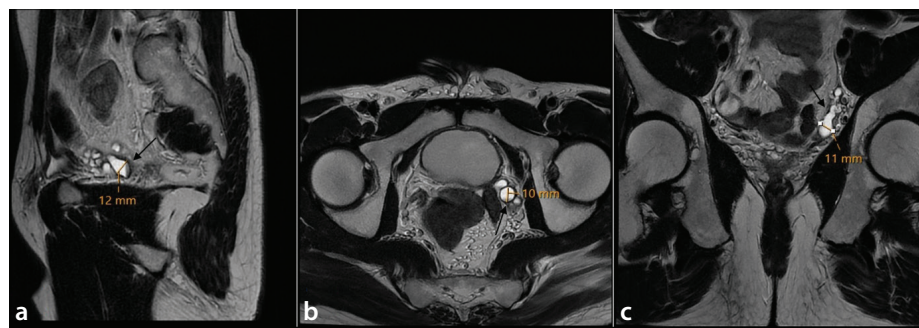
A 25-year-old patient with bilateral vasal agenesis and azoospermia. The T2-weighted sagittal (a), axial (b), and coronal (c) images show the intra-abdominal part of the left vas deferens dilatation (black arrows). Diagnosis was made by measuring the maximum diameter of the vas deferens.
